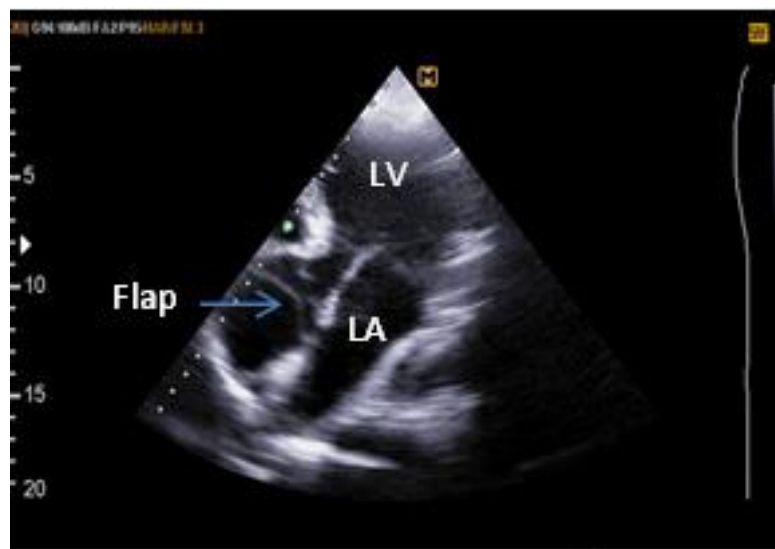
Transthoracic echocardiography (apical view) shows the dissection flap.
